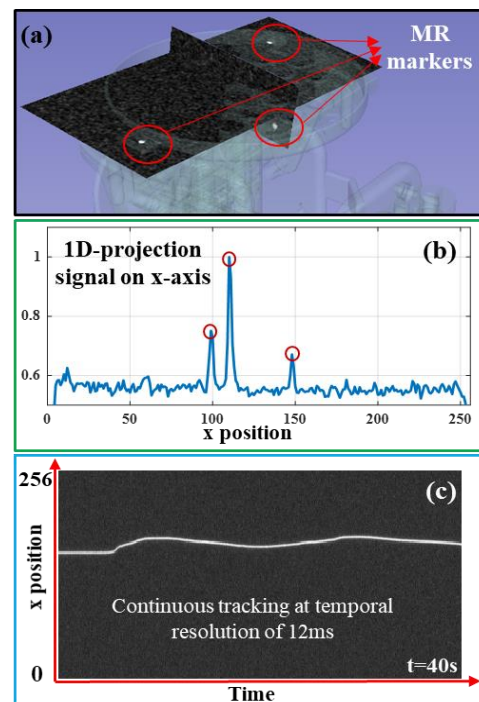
(a) Three MR marker positions obtained from MR image to register robot in MRI coordinates; (b) 1D projection signal of three markers along x axis; (c) Continuously projected position on x -axis acquired at 83.3Hz. The SNR is so high that a single point signal within 0-256 pixel can be contrasted and observed at each time step.
